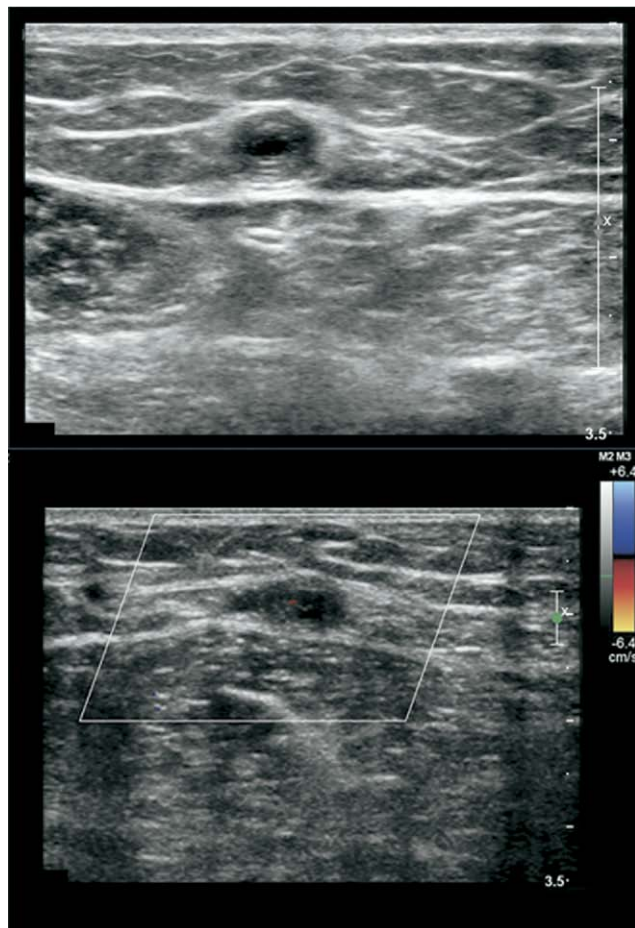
Normal appearance of GSV post-ELA. On the top image, the vein has a thickened wall. On the bottom image, there is no flow by color Doppler US. Other expected changes on US post-ELA (not shown) include a decrease in vein caliber and noncompressible vein over the treated segment.
